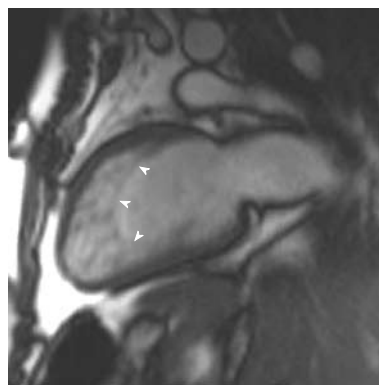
A 23-year-old man with Rubenstein-Taybi syndrome who presented with increasing shortness of breath. Vertical long-axis view demonstrating increased trabeculations at the apical ventricular level fulfilling cardiac magnetic resonance imaging criteria for left ventricular noncompaction.
